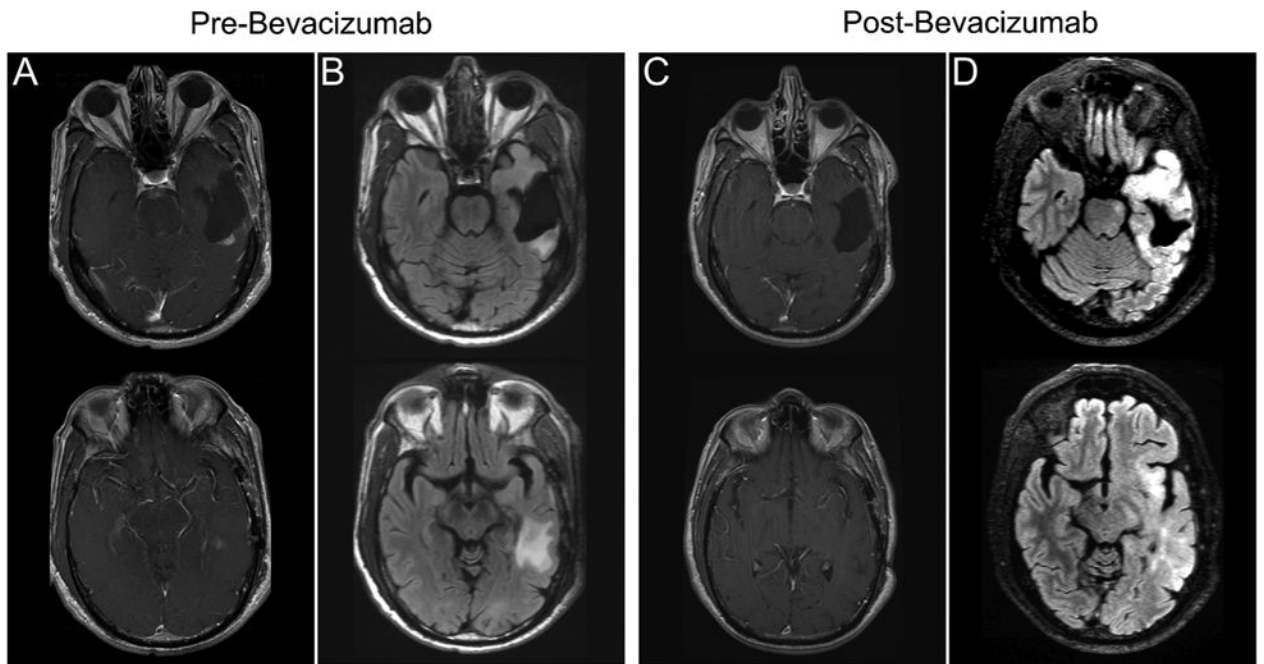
Disseminated progression following bevacizumab chemotherapy. T_1 -weighted gadolinium enhanced (A) and T_2 -weighted FLAIR (B) images of a recurrent glioblastoma in the left temporal lobe prior to bevacizumab therapy. After 12 months of bevacizumab therapy T_1 -weighted gadolinium enhanced (C) and T_2 -weighted FLAIR (D) images demonstrate non-enhancing disseminated tumor in the entire left temporal lobe extending into the left insula and cerebral peduncle.
